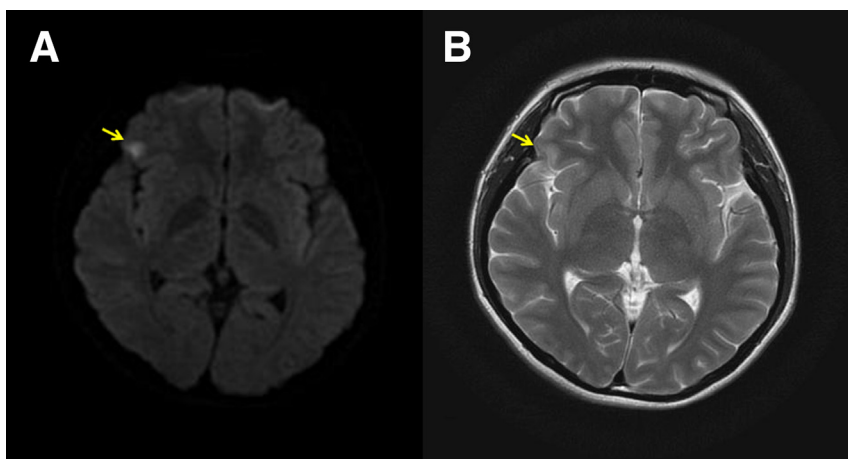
Diffusion-weighted imaging (A) and T2-weighted imaging (B) of initial magnetic resonance study demonstrating spotty acute infarction in the right frontal operculum (arrows).
